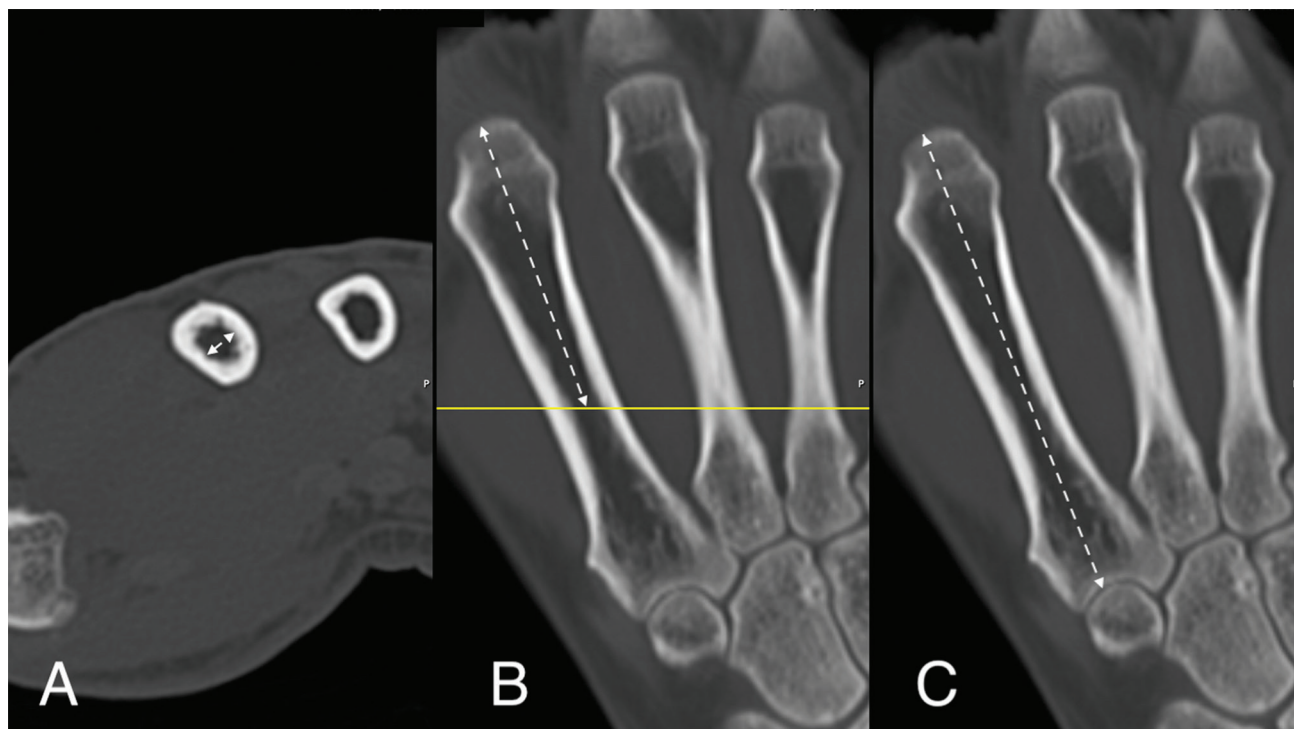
Computed tomography (CT) scan showing measurements of the index metacarpal. The yellow localizer line shows depict the isthmus level on coronal views. (A) Diameter of the isthmus, defined as the narrowest diameter of the intramedullary canal in the axial bone window. (B) Distance from the distal most aspect of the metacarpal head to the isthmus proximally. (C) Metacarpal length in the coronal bone windows.
